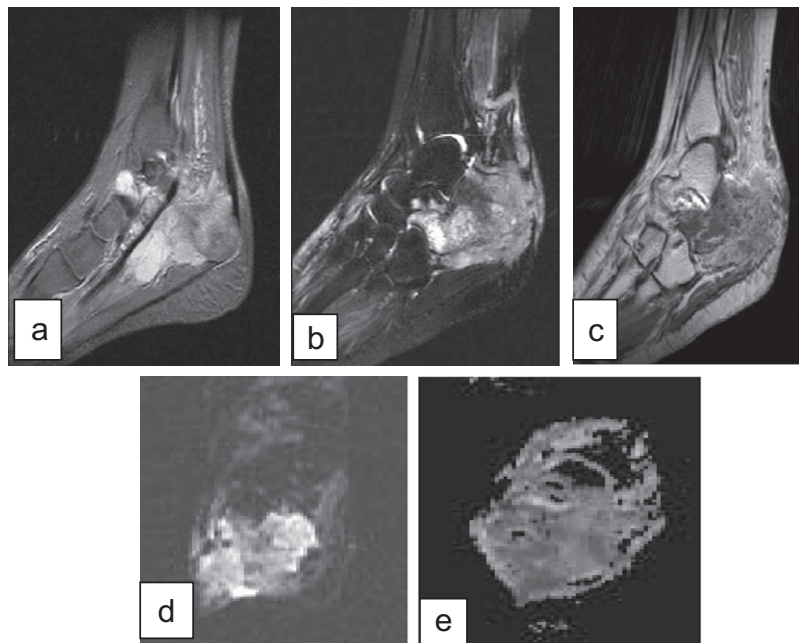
Mesenchyma chondrosarcoma of the calcaneus appears of high signal in sagittal STIR, T2 fat suppression (a,b) with non uniform contrast enhancement in post contrast sagittal T1WIs. restriction in DWI(d,e) and ADC. ADC Value 2.1 ± 0.32 .
